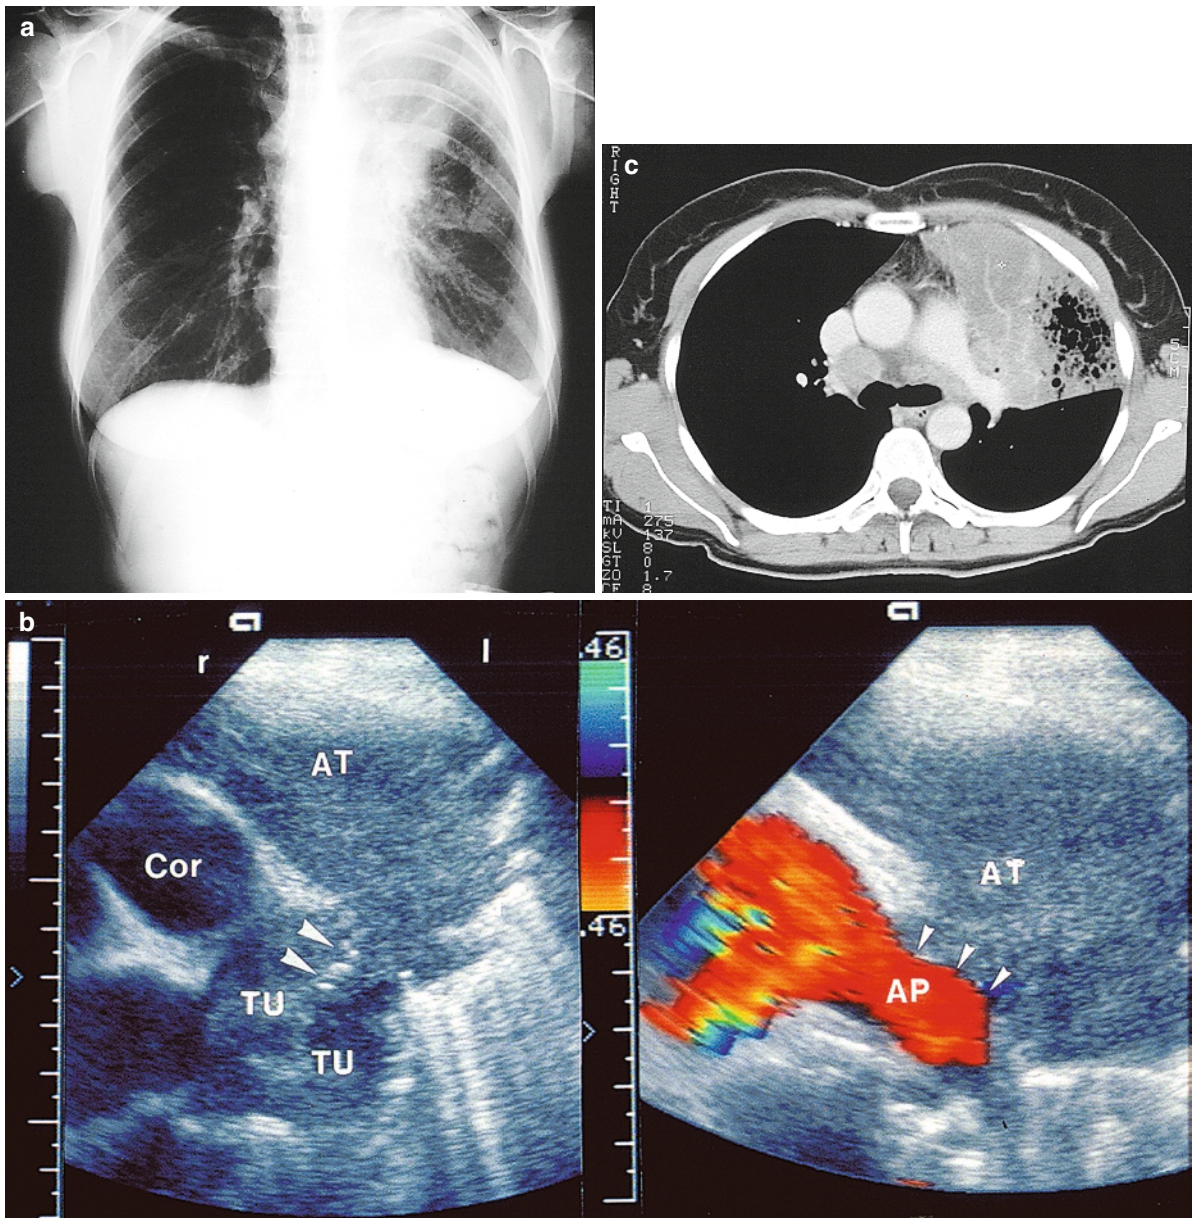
A 68-year-old man with a bronchial carcinoma. (a) Chest X-ray: signs of middle-lobe atelectasis. (b) Sonography: right-ventral intercostal echo transmission shows atelectasis in the middle lobe (*AT*) with accentuated dilated bronchi, indicative of a fluid bronchogram (“sticks”). The central tumor formation cannot be clearly demarcated. (c) Computed tomography: visualization of atelectasis in the middle lobe
